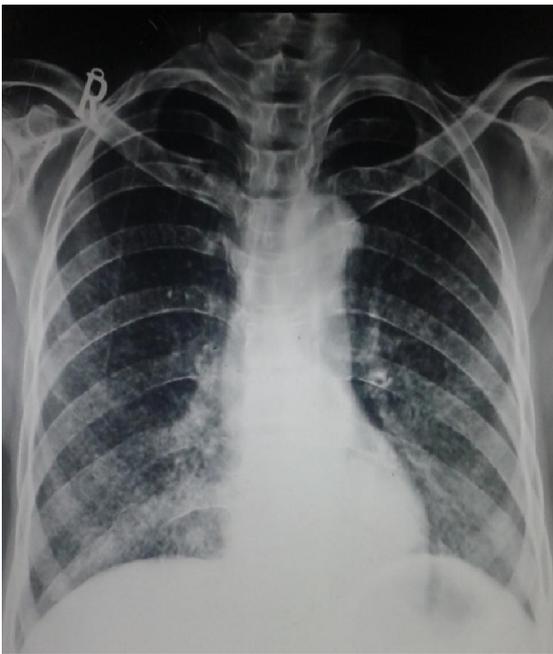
Chest Xray PA view showing millitary shadows
